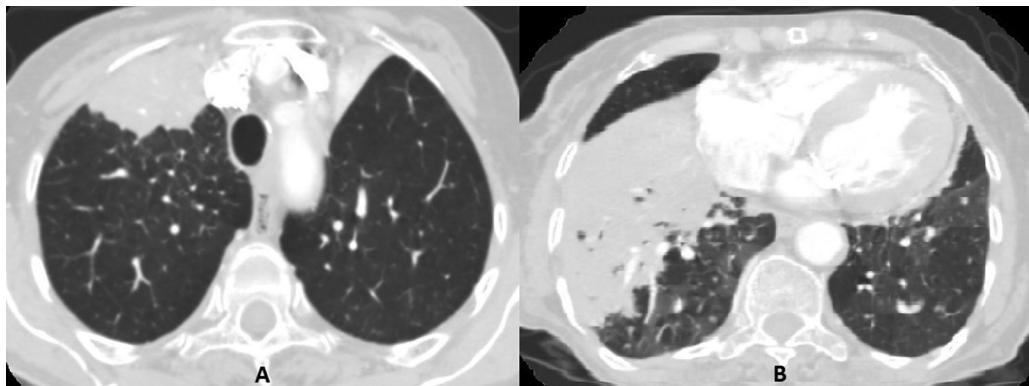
(A) High-resolution computed tomography (HRCT) of the thorax (lung window) showing consolidation in the right upper lobe. (B) High-resolution computed tomography (HRCT) of the thorax (lung window) showing consolidation in the right lower lobe.
